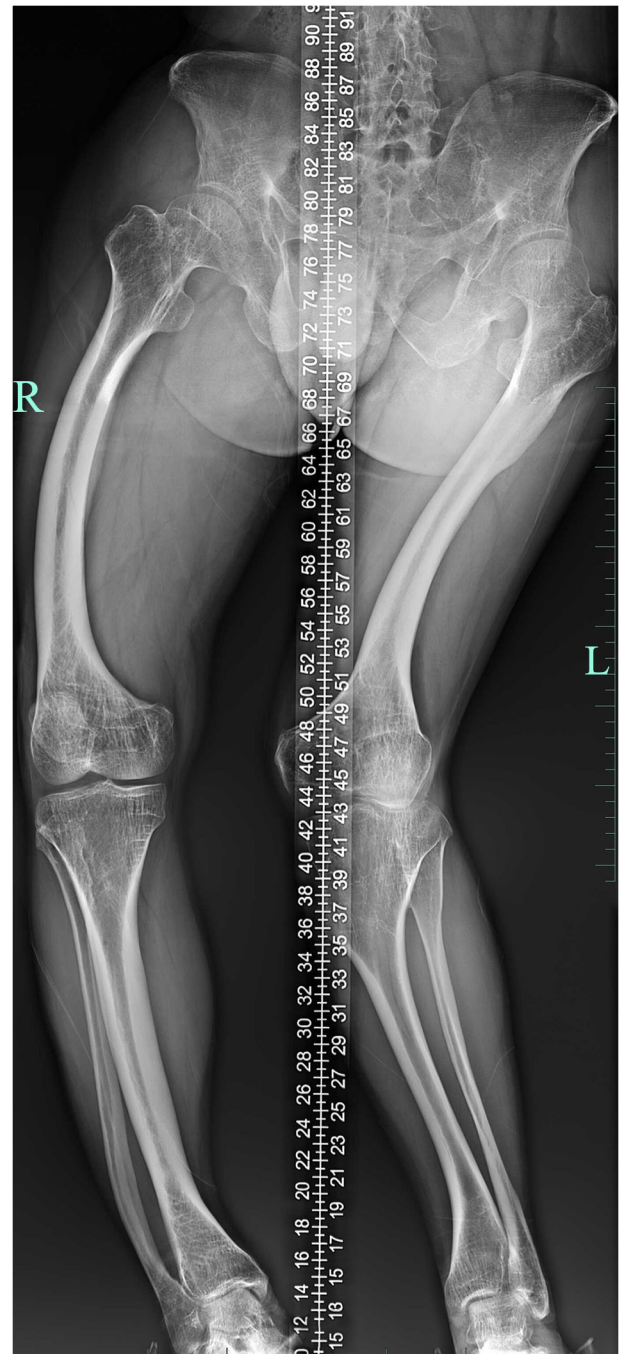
X-ray image demonstrating deformities in both lower limbs. The R means right side, and the L means left side.
